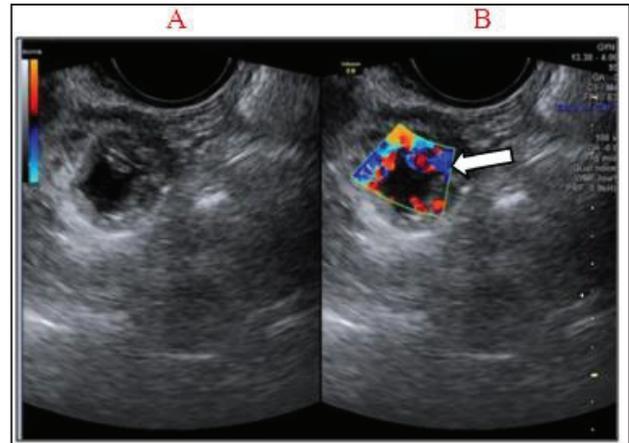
Axial transvaginal ultrasound images of right adnexa on grey scale (A) and color doppler (B). Cystic area in the adnexa was suspicious for ectopic pregnancy, color doppler showed a peripheral rim of blood flow (arrow), suggestive of ectopic pregnancy. This peripheral rim is also known as “ring of fire” sign.
